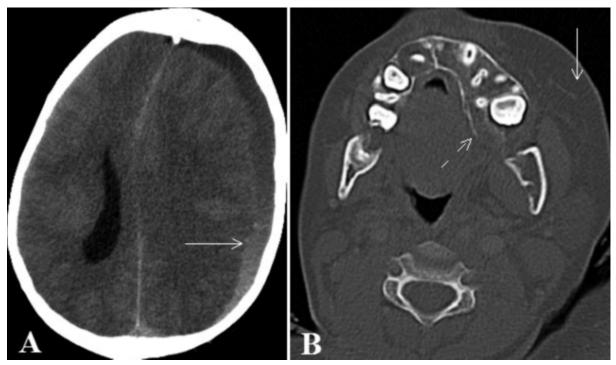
10-year-old girl with Klippel Trenaunay Syndrome. (A) Non-contrast CT brain shows a left frontoparietal subdural hemorrhage with fluid level causing significant mass effect and midline shift (arrow). (B) Non-contrast CT of the face with bone window shows the hypertrophied mandible (dotted arrow) and subcutaneous tissue of the cheek on the left side (arrow).
